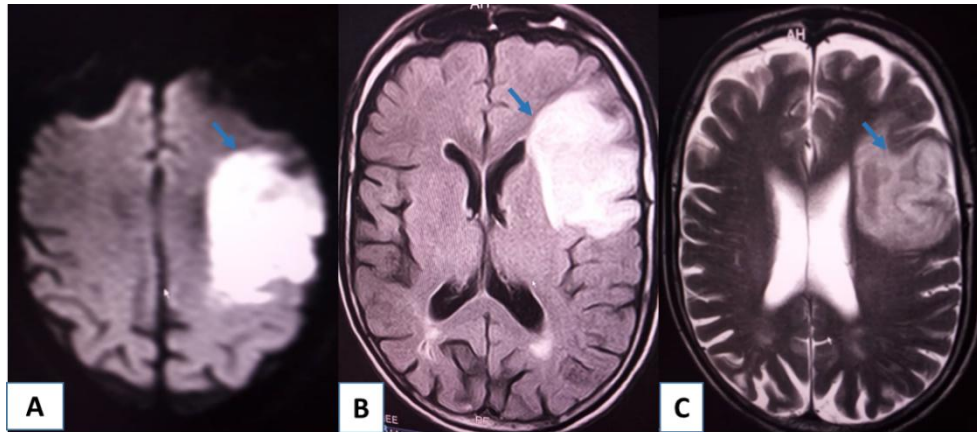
Cerebral MRI in axial slice in diffusion (A) FLAIR (B) and T2 sequence (C) showing left frontoparietal range described in hypersignal Diffusion, Flair and T2 ischemic.
